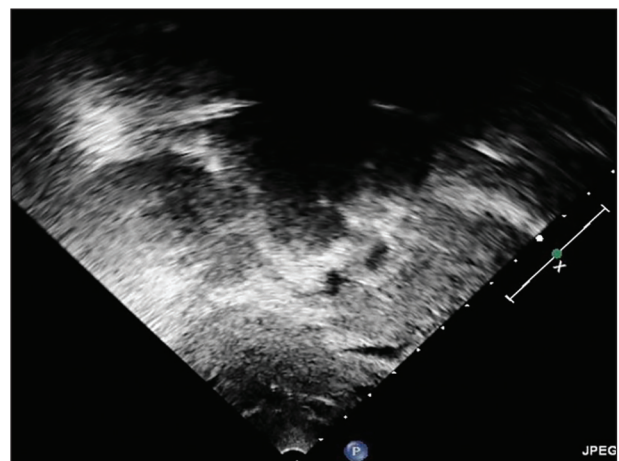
Two-dimensional (2D) echocardiography with subcostal coronal view showing the relationship of the aorta and inferior vena cava (IVC) suggestive of left isomerism
